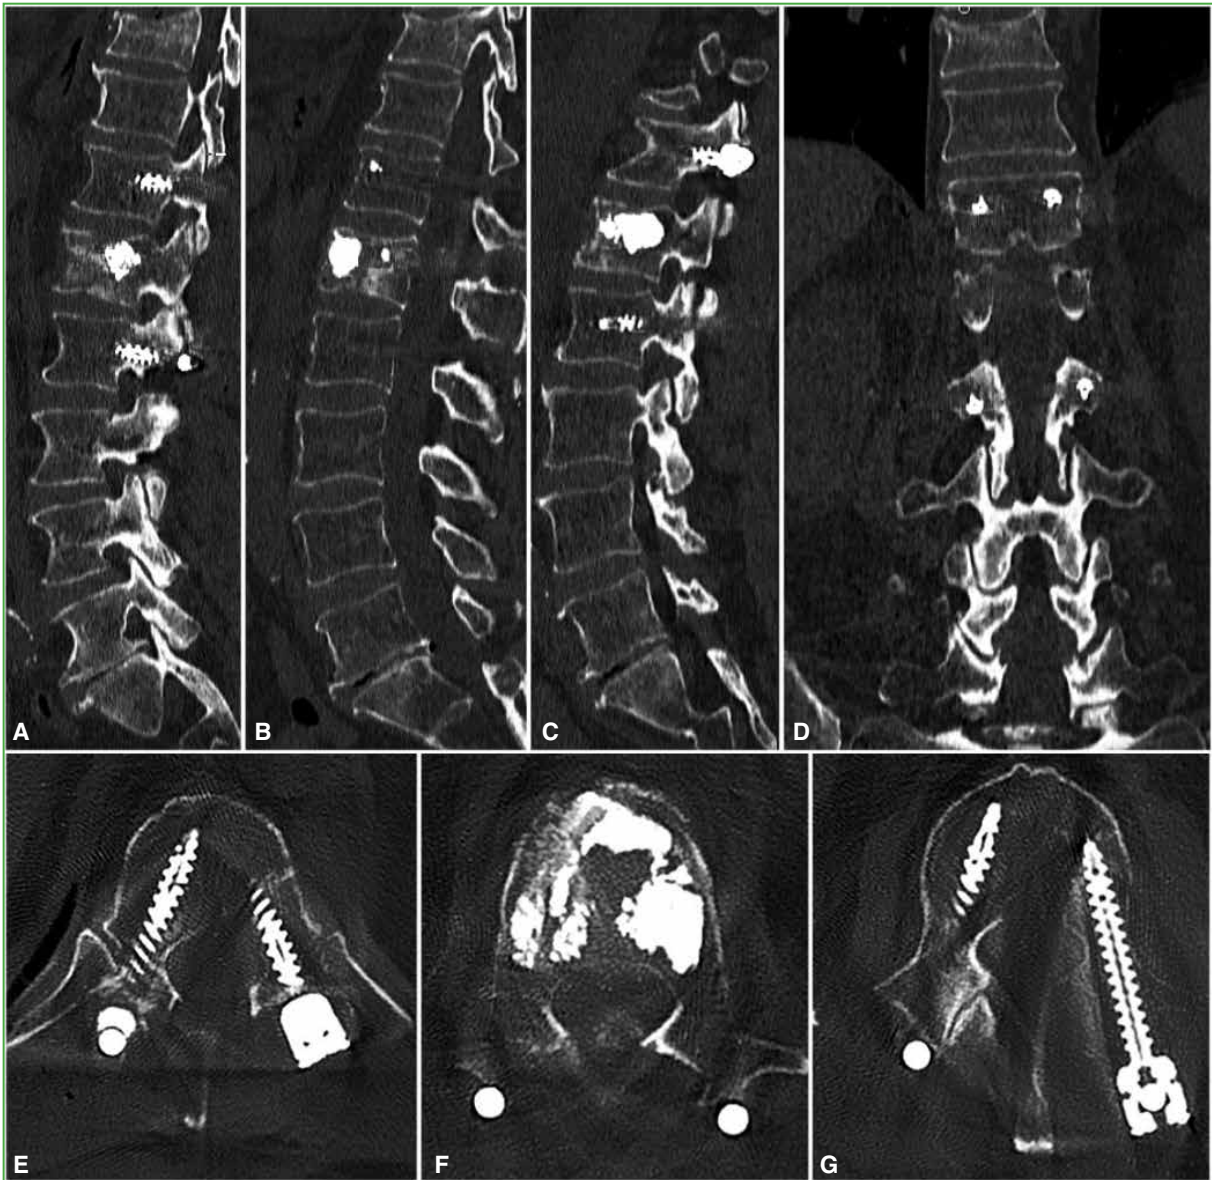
Immediate postoperative computed tomography of the thoracolumbar spine. Correct screw and cement positioning is observed. A. Left parasagittal section. B. Medial sagittal section. C. Right parasagittal section. D. Coronal reconstruction. E. Axial section at the upper instrumentation level. F. Axial section at the augmentation level. G. Axial section at the lower instrumentation level.
